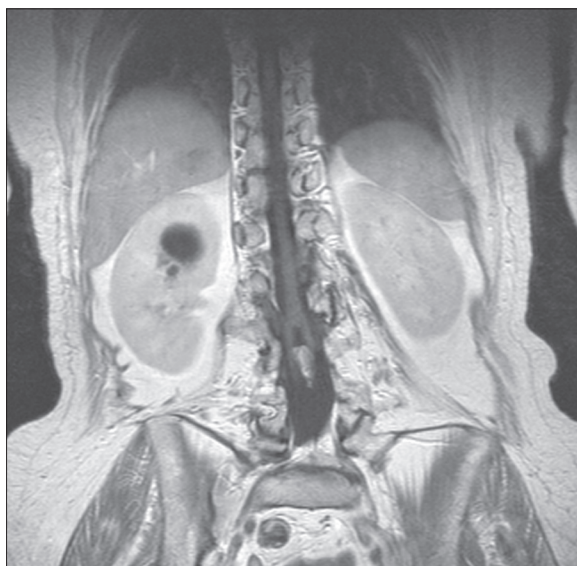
T1-weighted image, coronal plane. There is sagittal division of the spinal cord into two hemicords due to the presence of an osseocartilaginous septum.
